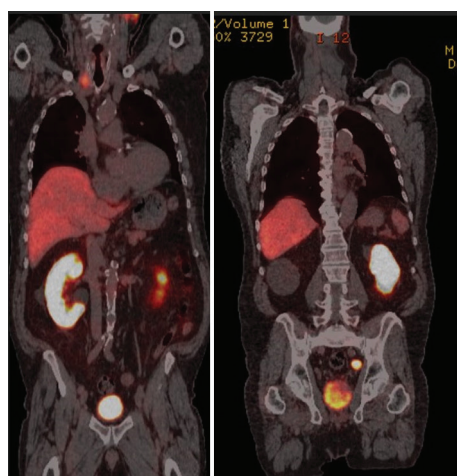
⁶⁸Ga-PSMA-PET/CT scans show primary prostate cancer with intense PSMA uptake in the iliac lymph nodes and other regions. The left image highlights multiple sites of uptake, while the right image focuses on the primary lesion and associated metastases.
